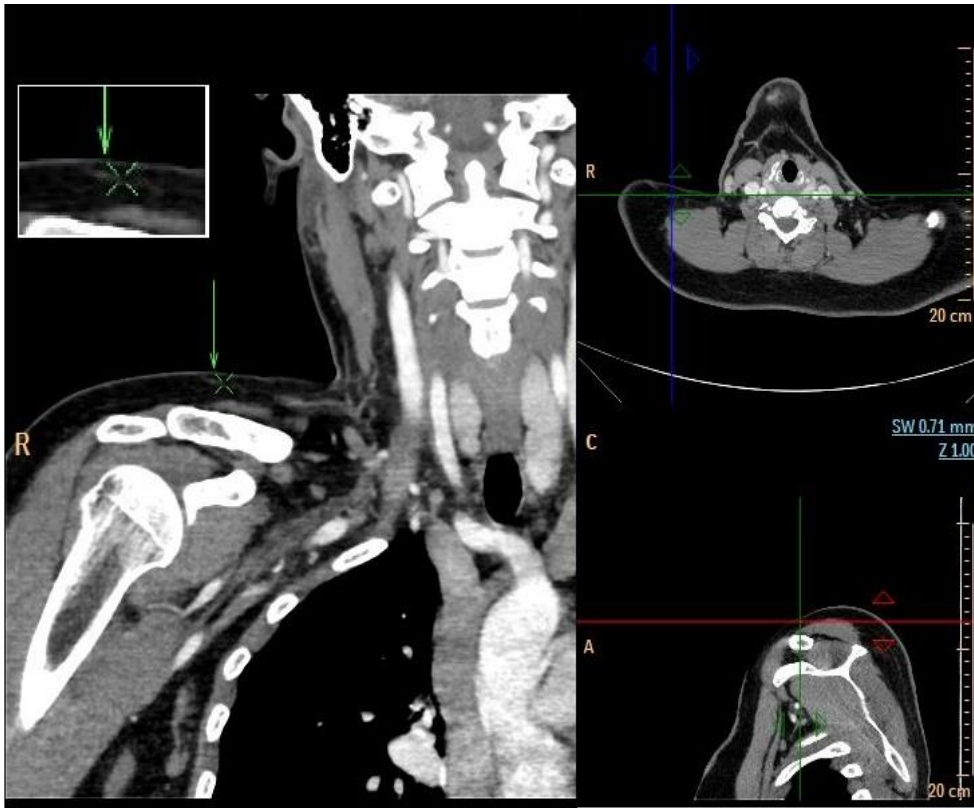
b: Computerized Tomography Angiogram (CTA) showed the vascular tree starting from thyrocervical trunk, transverse cervical artery, and supraclavicular artery perforator. A point on the supraclavicular artery marked on coronal section and shown by a cross cursor on the cross section and sagittal section.
